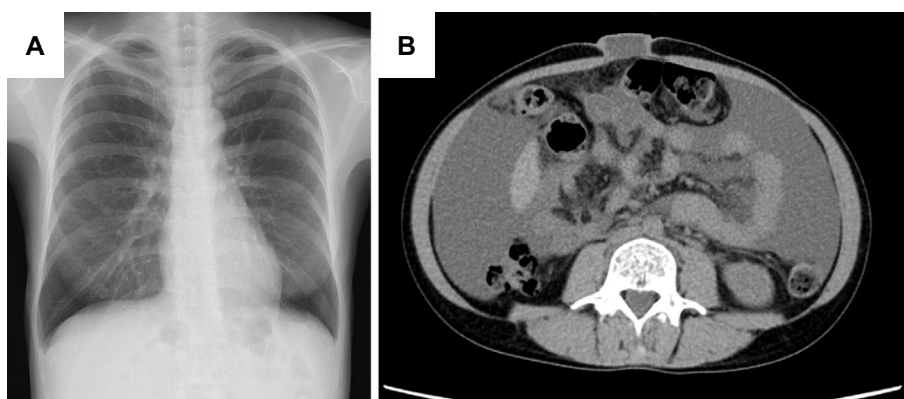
(A) Chest radiograph in April 2016 showed the disappearance of pleural effusion, and (B) abdominal CT showed ascites decreased and protruding navel improved.
